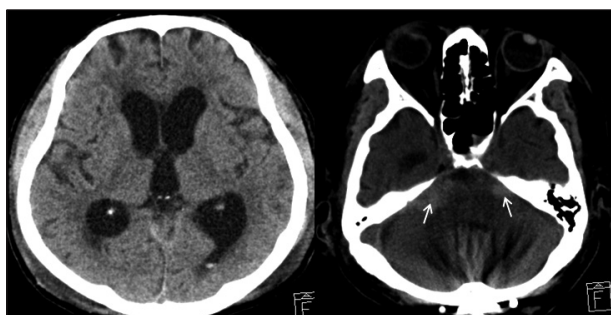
Brain CT shows marked enlargement of the lateral, third, and fourth ventricles. Also, SAH is observed in the cerebellomedullary cistern (arrows). CT : computed tomography, SAH : subarachnoid hemorrhage.
